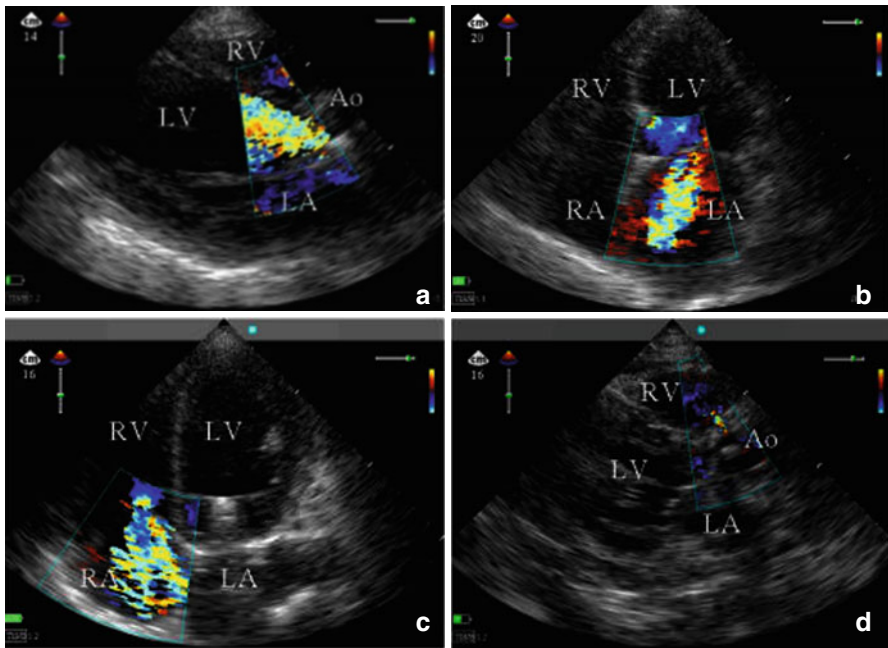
2D Doppler echocardiography. Examples of color Doppler mapping still frames obtained from handheld echocardiographic examinations of four distinct patients. (a) Parasternal long-axis view obtained from patient with massive aortic insufficiency. (b) Apical four-chamber view obtained from a patient ventilated for an acute pulmonary edema and associated systolic murmur. (c) Apical four-chamber view obtained from a ventilated patient with shock. (d) Parasternal long axis view obtained from a patient presenting with septic shock and new onset systolic murmur (From Vignon et al. [11]. © 2003; licensee BioMed Central Ltd; <http://ccforum.com/content/7/5/R84>)
